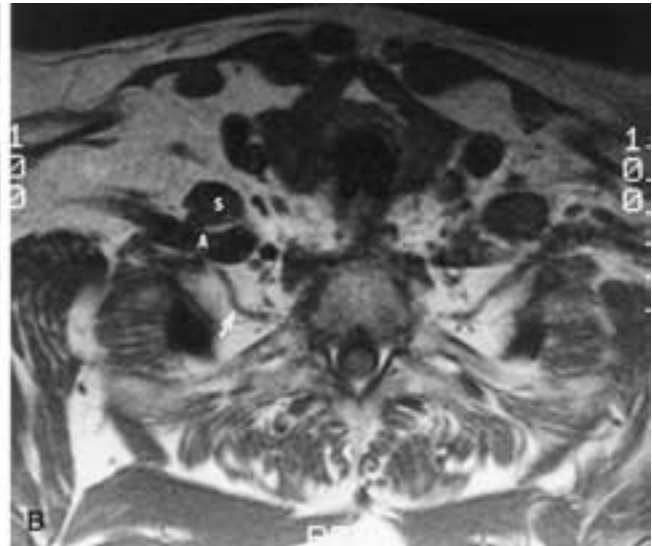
Lower trunk of the brachial plexus. Axial CT scan (A) and axial MR image (B) obtained at the level of the thoracic inlet show the T1 nerve root (arrow) on either side traveling medial to the lung apex to join nerve root C8 behind the subclavian artery (A). Note that the anterior scalene muscle (S) is anterior to the artery at this level.
